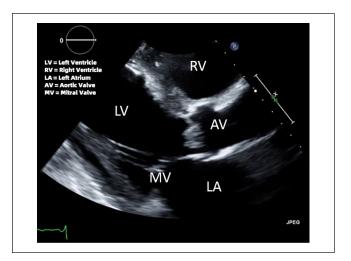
Transthoracic echocardiography showing vegetation attached to the aortic valve.
